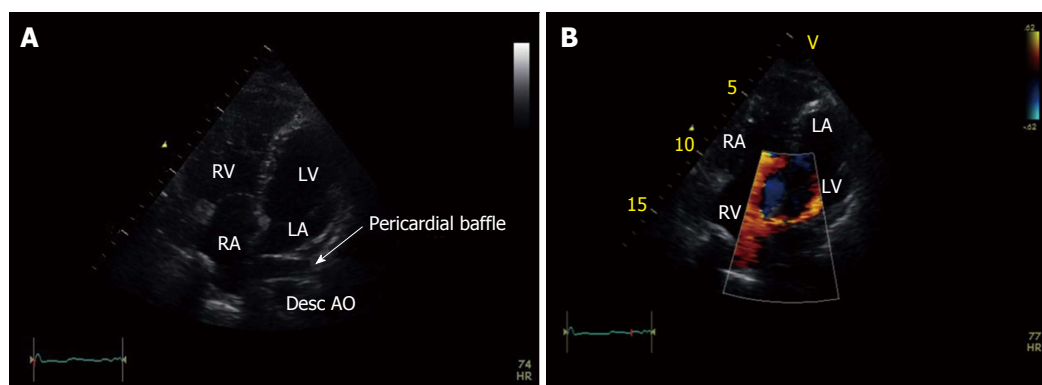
Apical 4-chamber view. A: The Mustard procedure employs a pericardial baffle to direct systemic venous return to the left ventricle and pulmonary venous return to the right ventricle; B: With color Doppler. The deoxygenated blood from the vena cavae is directed to the mitral valve and thence into the left ventricle which is the pumping ventricle for the pulmonary artery and the pulmonary circulation. LV: Left ventricle; RV: Right ventricle.
